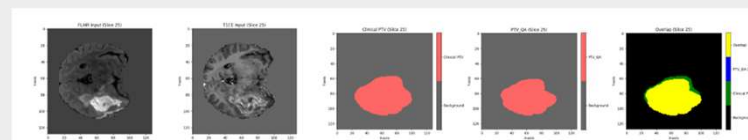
A sample segmentation comparing the input MRI images (FLAIR & T1CE), the clinical PTV and predicted test segmentation, A visual representation of the overlap between the clinical PTV and PTV_QA.
